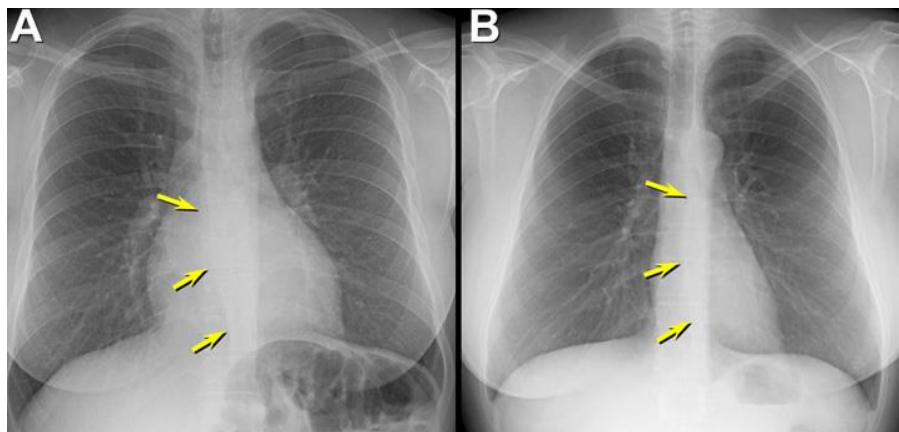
Frontal chest radiographs in 2 separate patients showing the normal interface created between the medial right lung and the medial right mediastinal region, referred to as the ayzgoesophageal recess. In these patients, the ayzgoesophageal recess describes a gentle, “S”-shaped curve.
